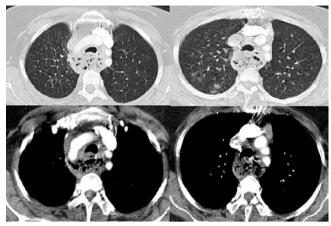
Thorax CT scan showed air and high-density liquid collections in mediastinal compartments
